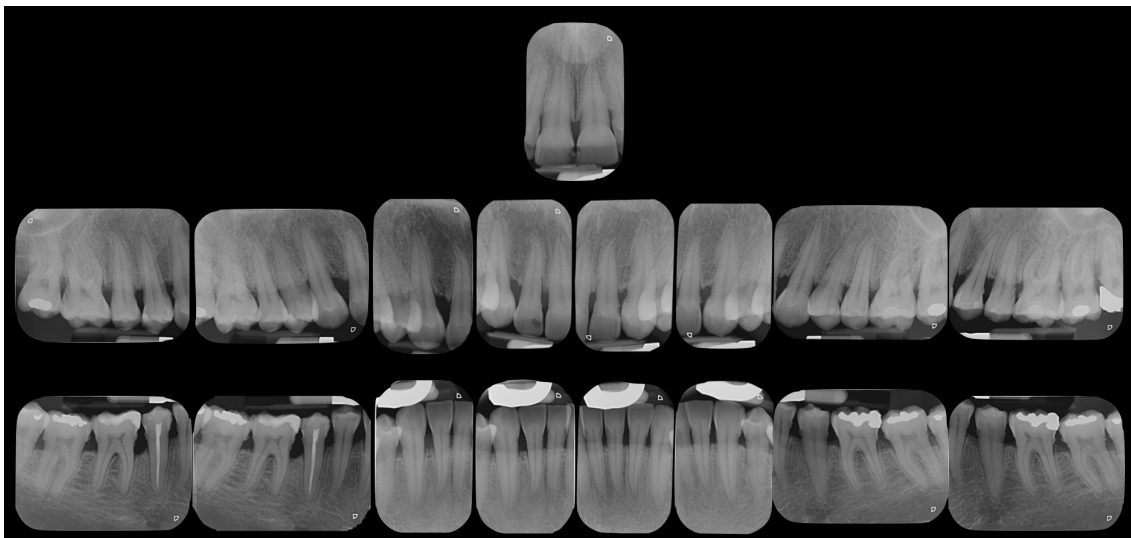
Complete apico-periapical status
